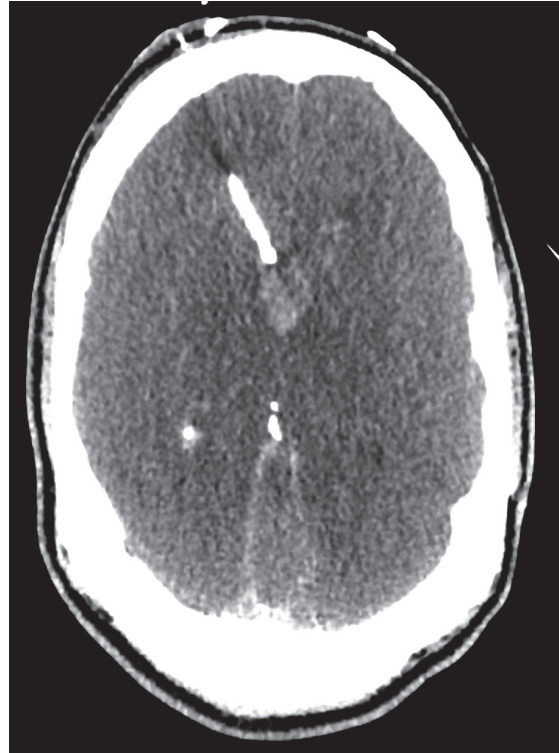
Follow-up CT examination after 34 hours.
